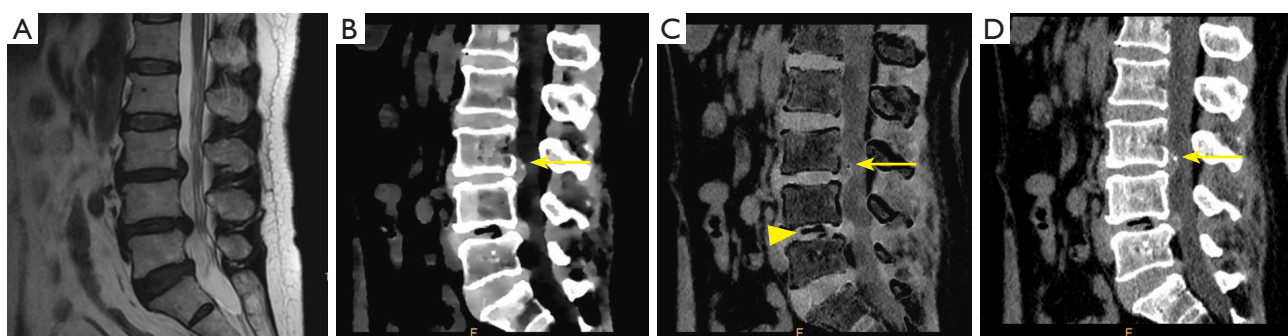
A 54-year-old female with left lower limb pain. (A) Sagittal T2-weighted image showing lumbar disc bulging at the L3/L4, L4/L5, and L5/S1 levels. (B) ED image providing clearer visualization compared to (C) VNCa and (D) SC. Disc calcification at the L3/L4 level [yellow arrows in (B-D)] visible on ED and SC images but subtracted and appearing black and the same as disc gas accumulation on the VNCa image [yellow arrowhead in (C)], thus being indistinguishable on sagittal T2-weighted imaging. ED, electron-density; VNCa, virtual noncalcium; SC, standard computed tomography.
